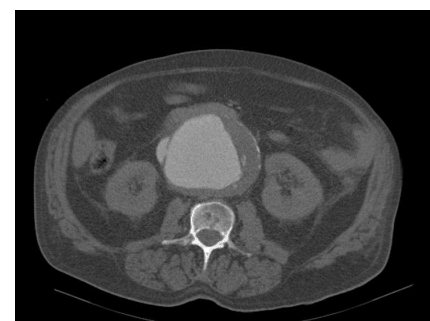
CT scan with contrast. Abdominal aorta aneurism and aortocaval fistula
